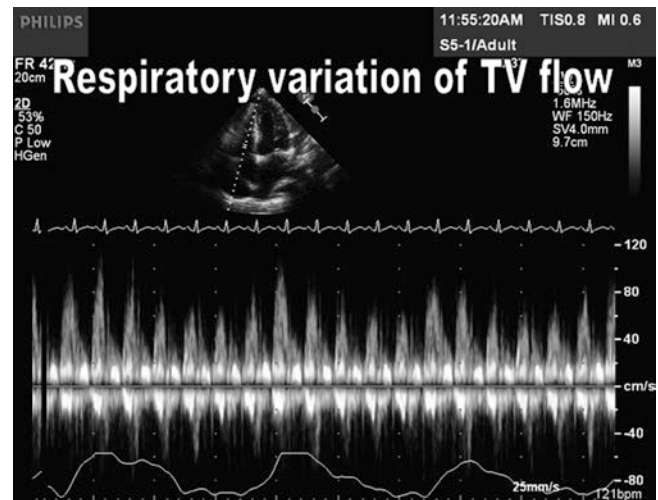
Respiratory variation of tricuspid valve flow detected by Doppler flow imaging in a patient with cardiac tamponade. *TV* tricuspid valve
